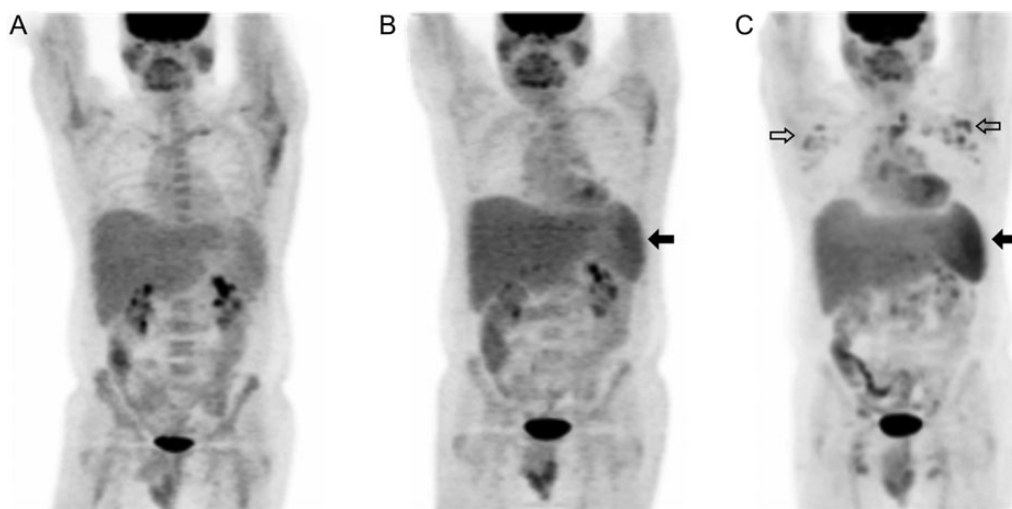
Progressive ^{18}F -fluorodeoxyglucose (^{18}F -FDG) positron emission tomographic (PET) abnormalities preceding symptomatic relapse of Kaposi sarcoma herpesvirus-associated multicentric Castleman disease (KSHV-MCD). Panels show sequential ^{18}F -FDG PET scans performed in a single patient at time points after the first remission of symptomatic KSHV-MCD. Maximum intensity projections are shown. *A*, At first remission, the only metabolic abnormality was a mild increase in isolated axillary nodes. *B*, Four months into remission, while the patient was still clinically asymptomatic, splenic metabolism was mild with borderline splenomegaly (closed arrow); nodal abnormalities were slightly more prominent. *C*, Ten months into remission, while the patient was still asymptomatic, splenic metabolism was markedly increased with persisting borderline splenomegaly (closed arrow), and moderately hypermetabolic adenopathy was seen, most marked in the axillary nodes but also involving cervical and inguinal sites (open arrows). Two months later, the patient experienced a symptomatic relapse and was enrolled in the present study and treated. These abnormalities resolved completely with his second remission (not shown).
